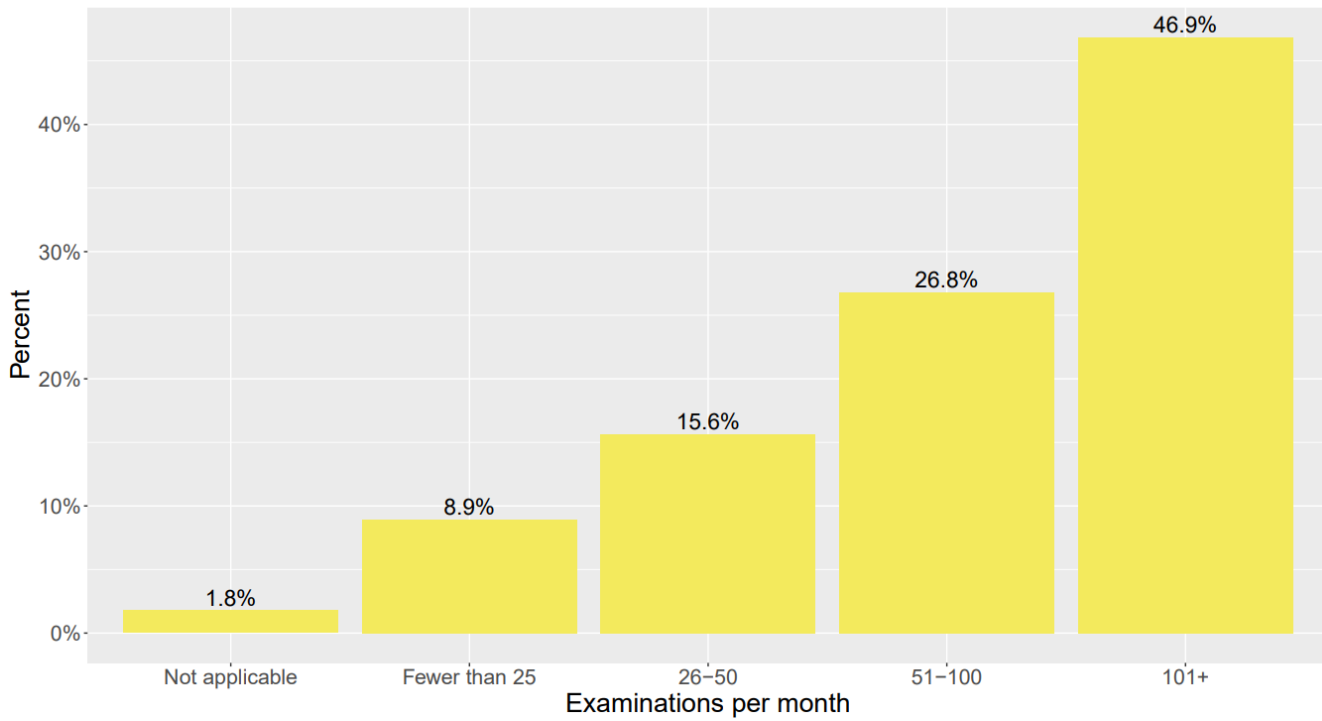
AE ultrasound exams performed per month in 2018 survey responses
